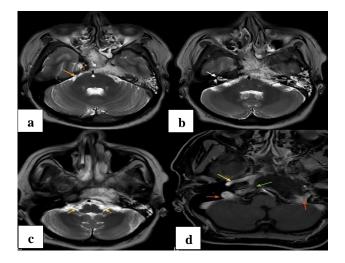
(a) This is a T2-weighted MR venogram of the brain in axial section. The white arrow shows tumor infiltrating the sela tercica and the yellow arrow shows normal right trigeminal nerve. The red and yellow arrows depict right ICA and ECA respectively, compare all structures to the left side. White arrow head shows patent basilar artery; (b) the white arrow shows right vestibulofacial facial nerve, compare with left side where tumor has infiltrated the nerve. The abducens nerves are not visualized because of tumor infiltration, (c) the glossopharyngeal and vagus nerve shown exiting the brainstem on both sides, and (d) the red arrow indicated the sigmoid sinus on the right and left side. The yellow arrow is the ICA. The green arrow is the inferior petrosal sinus. Compare the course of glossopharyngeal and vagus nerves with respect to jugular bulb on right side. Tumor has completely distorted the jugular anatomy.
